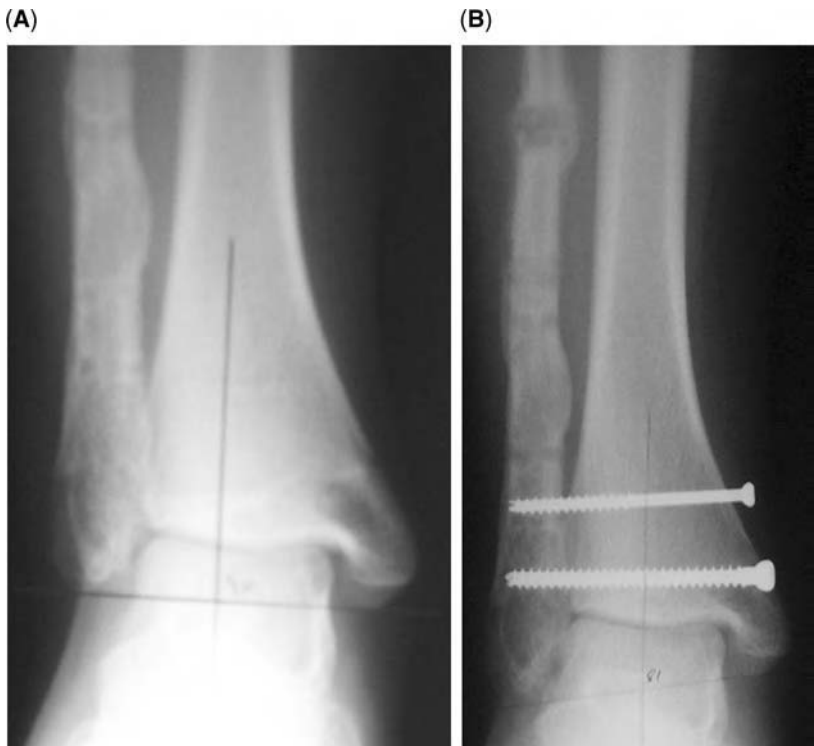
(A) Anteroposterior X-ray showing relative shortening of the fibula. (B) After fibula lengthening and insertion of syndesmosis screws.
